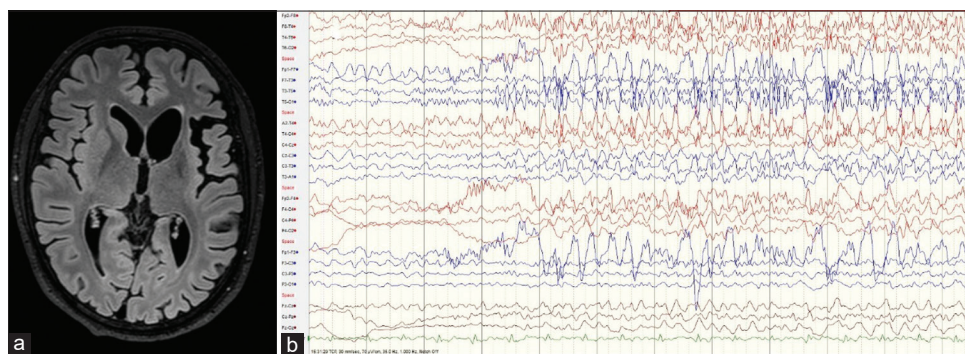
(a) MRI Brain demonstrating left hemispheric atrophy (predominantly perisylvian, caudate and putamen). (b) EEG showing 3.5–4 Hz spike and wave discharges and polyspikes localised to the left frontal lobe
